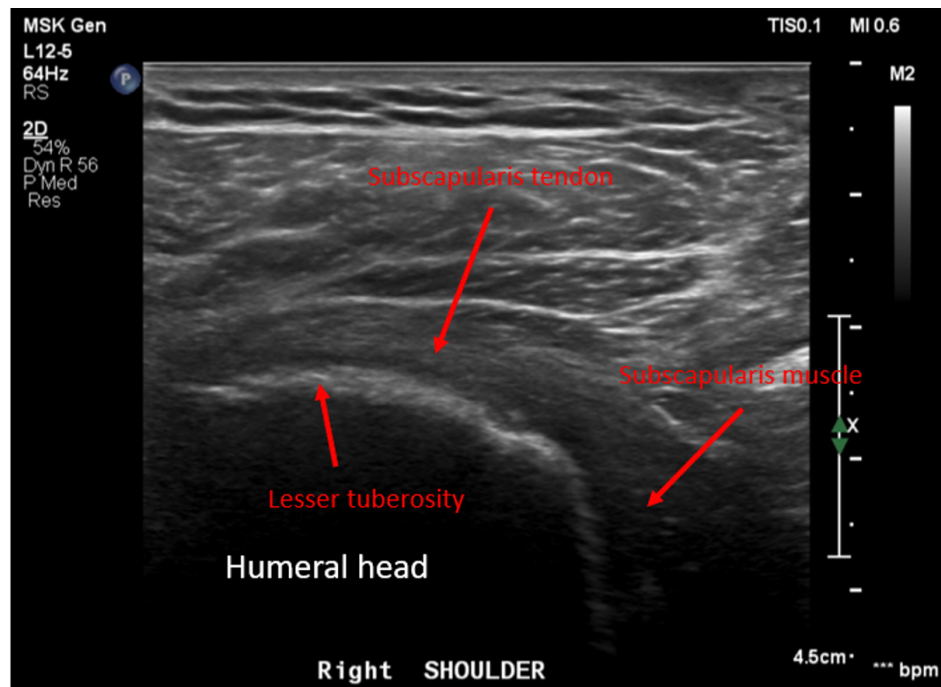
Patient #2 representative 6-month post-operative ultrasound demonstrating an intact subscapularis tendon with normal collagen fibrillar architecture with visibly aligned collagen fibers and anatomic size measurements.
